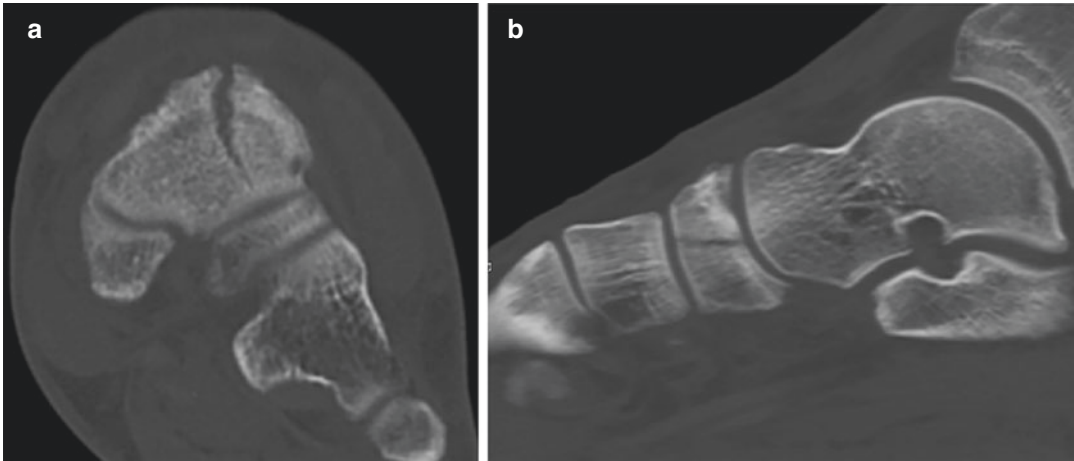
CT scan of an elite football player with a navicular stress fracture. (a) Axial CT view, (b) sagittal CT view
